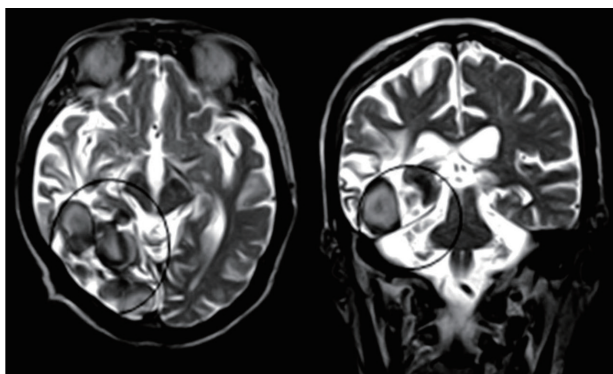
Horizontal (left) and coronal view (right) of brain MR image of an 80-year-old man who presented with dementia. Complicated cystic structures and calcifications (circles) are seen mainly in the right occipital lobe, with encephalomalacias in the right occipital and temporal lobes.
